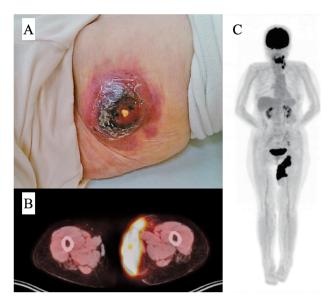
Macroscopic and 18F-fluoro-2-deoxy-D-glucose–positron emission tomography (FDG-PET) findings Photograph of the left inner thigh during the initial consultation at Hospital A showing a lesion measuring 8 × 8 cm (A). FDG-PET insights: a mass of 10 cm is observed in the left thigh, showing FDG uptake (B). Whole-body FDG-PET scan: multiple areas of FDG uptake in the left inner thigh, left inguinal and cervical lymph nodes, tonsils, and the anterior wall of the mid-pharynx can be observed (C).
